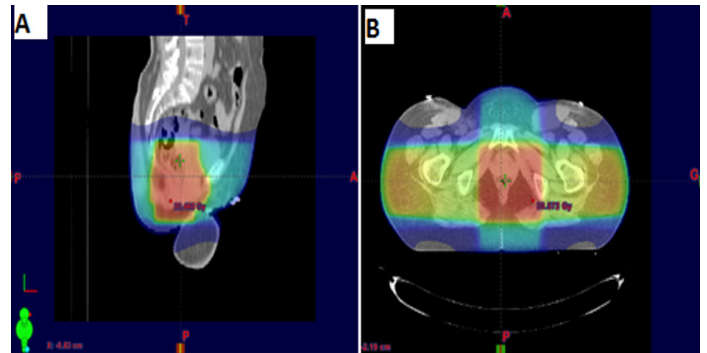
3D conformational radiotherapy of the adenoid cystic carcinoma of vulv showing the dose's distribution of the Boost (A: Sagittal CT scan image; B: Axial CT scan image)
